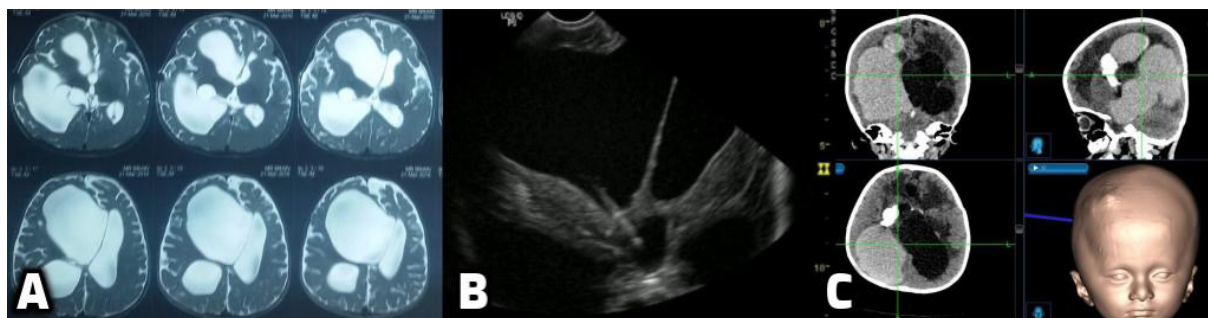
A: MRI T2W axial section showing multiloculated hydrocephalus; B: ultrasound image for guidance of septostomy; C: navigation image showing successful septostomy with passing of catheter to the opposite ventricle
